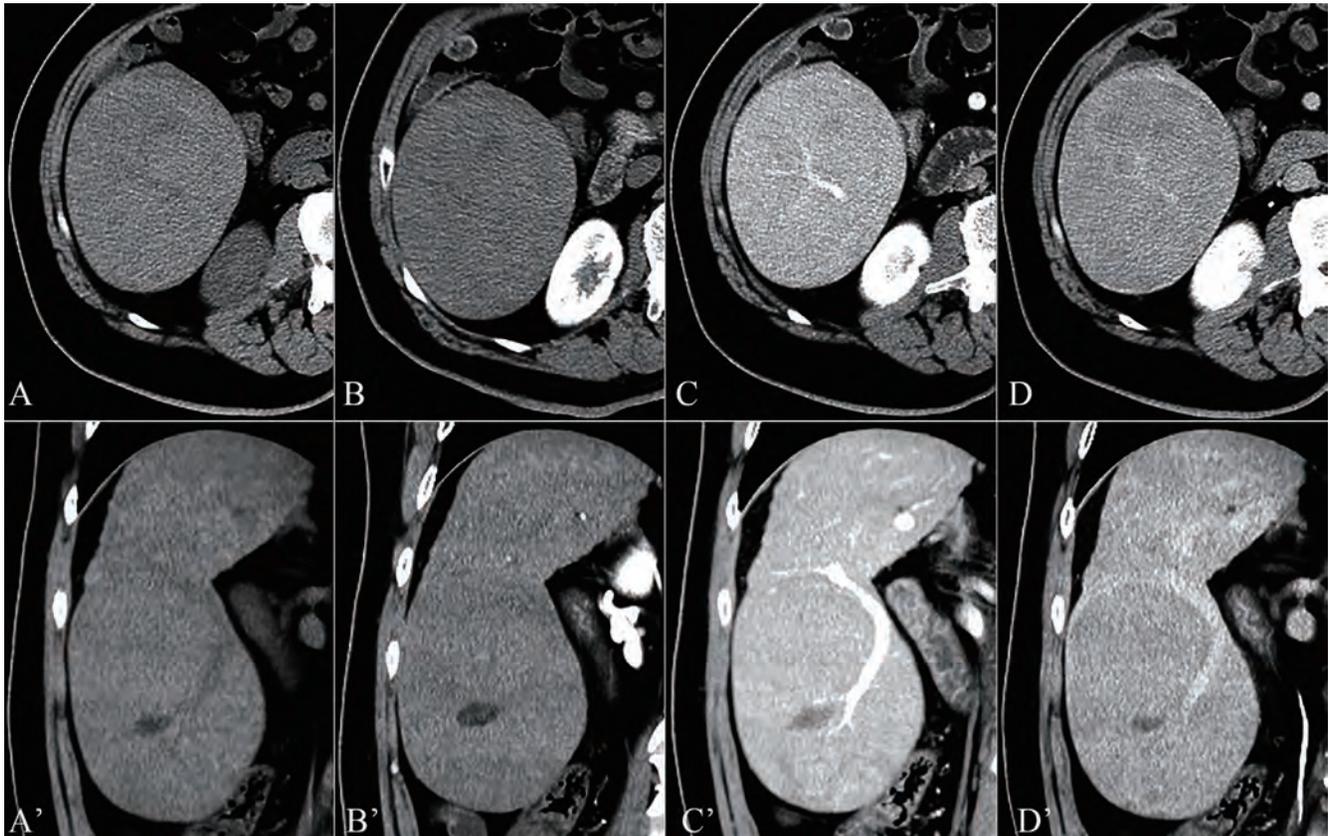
CT images of a giant hepatic mass. (A and A') Precontrast CT scan shows a well-circumscribed oval hypodense mass with an average attenuation of 50.5 HU in segment VI of the liver, including a focal hypodense area (18.5 HU) and extending downward to the right iliac fossa. (B and B') Contrast-enhanced CT scan in the arterial phase showing a nodule (53.5 HU) with a density similar to that of the surrounding liver cirrhosis (52.0 HU). (C and C') The portal phase shows that the mass density (91.3 HU) was slightly greater than that of the surrounding liver cirrhosis (83.0 HU), with a portal vein branch crossing through the lesion. (D and D') The delayed phase shows a mass density (77.3 HU) that is slightly lower than that of the surrounding liver cirrhosis (81.0 HU). The focal hypodense area within the lesion was not enhanced from the arterial phase to the delayed phase. A–D, axial images; A'–D', coronal reformation images. CT, computed tomography; HU, Hounsfield units.
